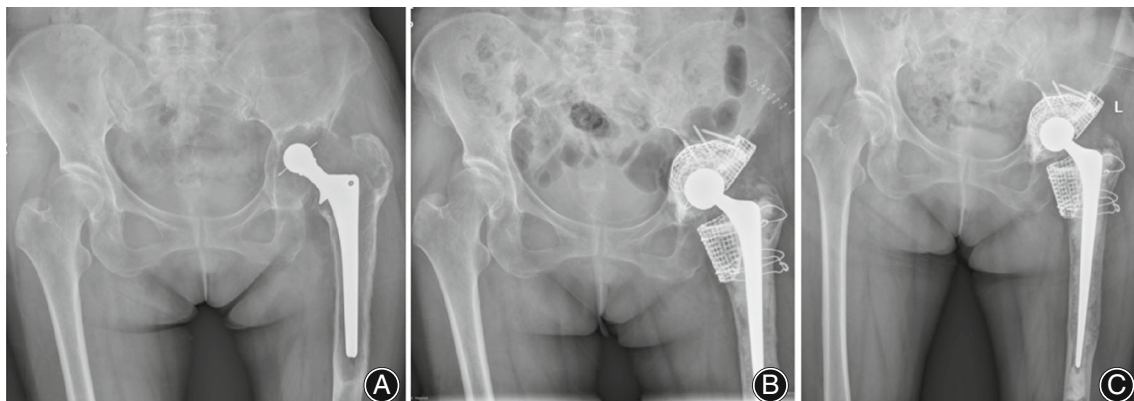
(A–C) Preoperative and follow-up radiographs of the left hip joint in a 66-year-old woman. (A) The preoperative pelvic AP view of a female shows aseptic loosening and severe bone loss on both the acetabular and femoral sides. (B) Radiography at 1 week after she received a revision THR using IBG and meshes on both the acetabular and femoral side to restore the bone deficiency. (C) A radiograph at 12 months after the revision surgery on the left hip shows no radiographic loosening or cup migration.
